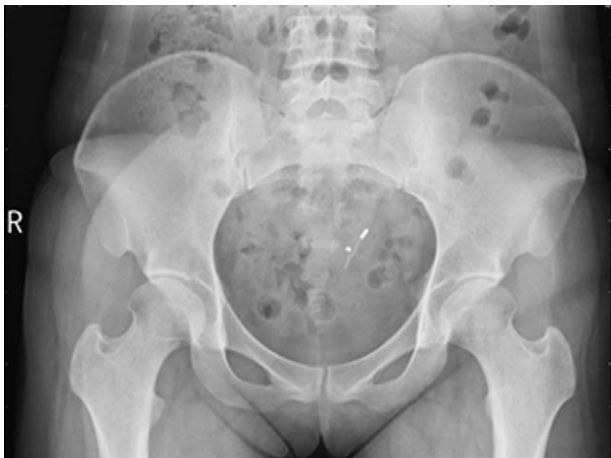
Abdominal x-ray confirmed the presence of the IUD in the pelvis. IUD=intrauterine contraceptive device.
